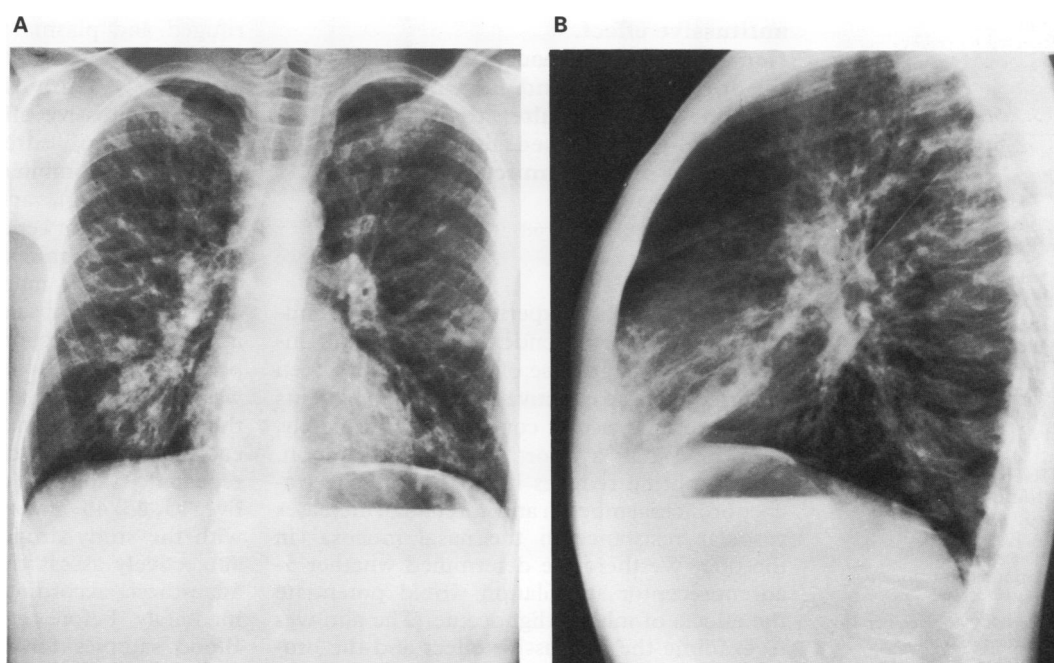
(A) Posteroanterior and (B) lateral chest radiographs scored as severely hyperinflated by both observers. Total lung capacity measured radiographically and plethysmographically was normal.
